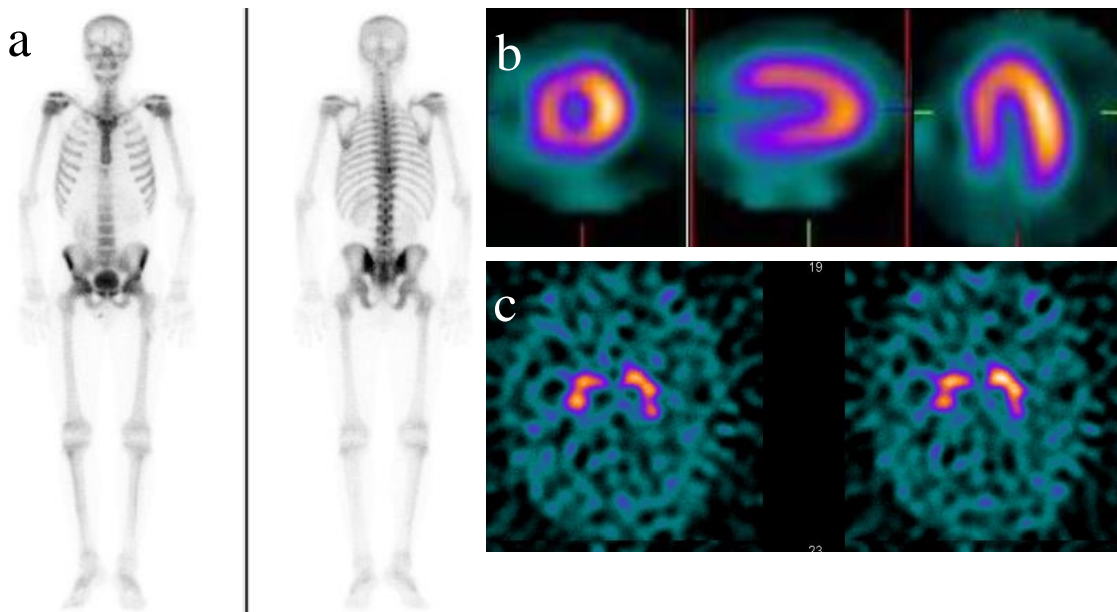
Example of (a) whole body bone scintigraphy (anterior and posterior views; images taken from [4]) and 3-D SPECT images. (b) Myocardial perfusion study (short axis, horizontal and vertical long axis views) showing the radiotracer distribution in the different regions of the myocardium ( images taken from [3]); (c) Transverse slices of the reconstructed brain SPECT image of  $^{123}\text{I}$ -Ioflupane (DaTscan<sup>TM</sup>).
